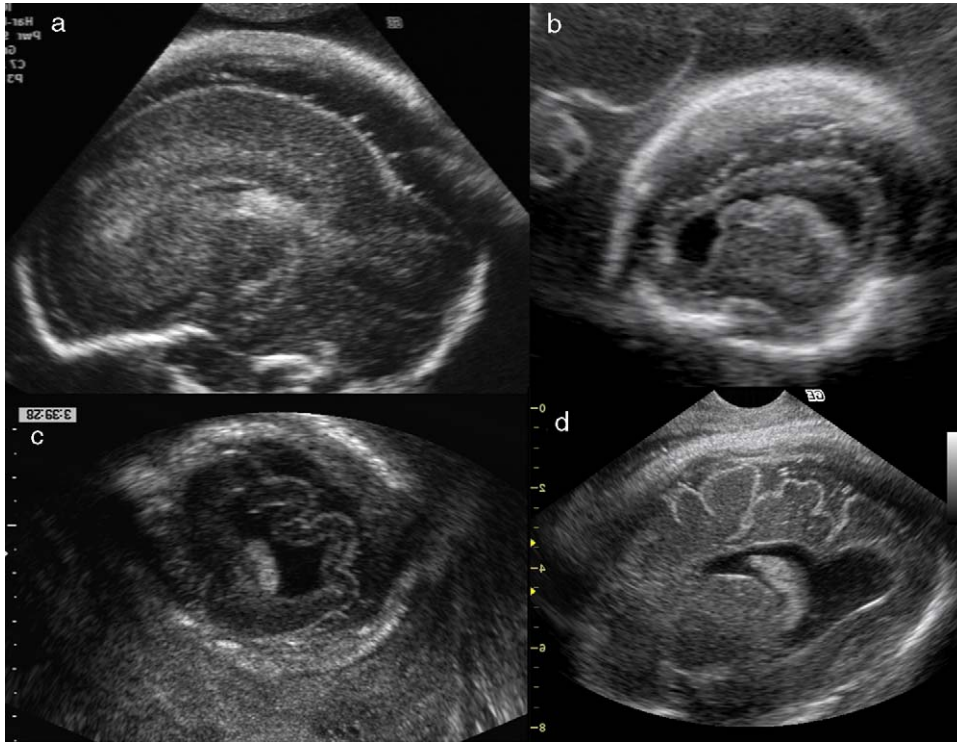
Ultrasonographic patterns associated with migration disorders. (a) Lack of normal sulcation at 28 weeks; (b) thin and irregular cortex at 26 weeks; (c) abnormal overdeveloped sulci at 22 weeks; (d) wide and deep sulci at 31 weeks.
